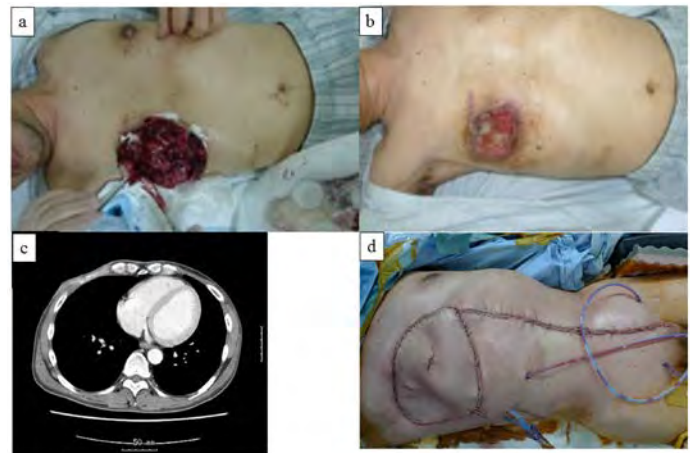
a Appearance after cutting the surface of the tumor. b Pre-operative physical appearance of the chest wall. The tumor has shrunk remarkably. .Axial computed tomography demonstrates disappearance of the tumor. d.Wide resection and reconstruction with a rectus abdominis musculocutaneous flap were performed.
